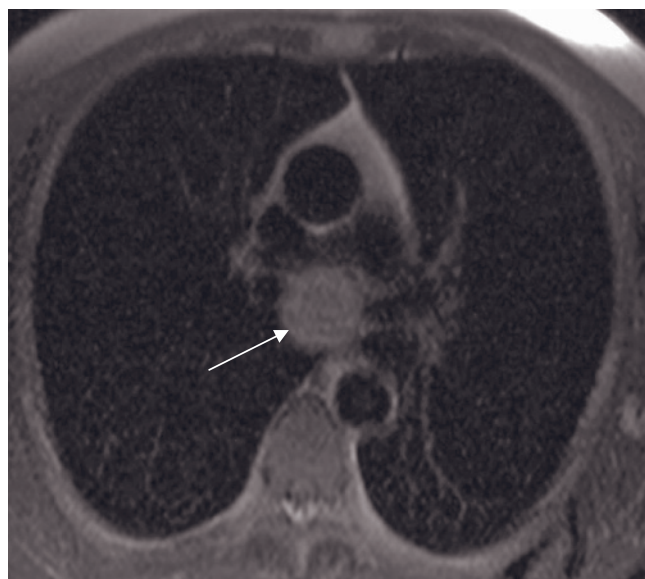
Mediastinal lymphadenopathy. T2-weighted ETSE (*a*) and postgadolinium fat-suppressed 3D-GRE (*b*) images demonstrate enlarged mediastinal lymph nodes (arrows, *b*) and left hilar adenopathy compressing the left pulmonary artery (curved arrow, *b*). T2-weighted ETSE (*c*) and postgadolinium 3D-GRE (*d*) images in a different patient demonstrate a large right
